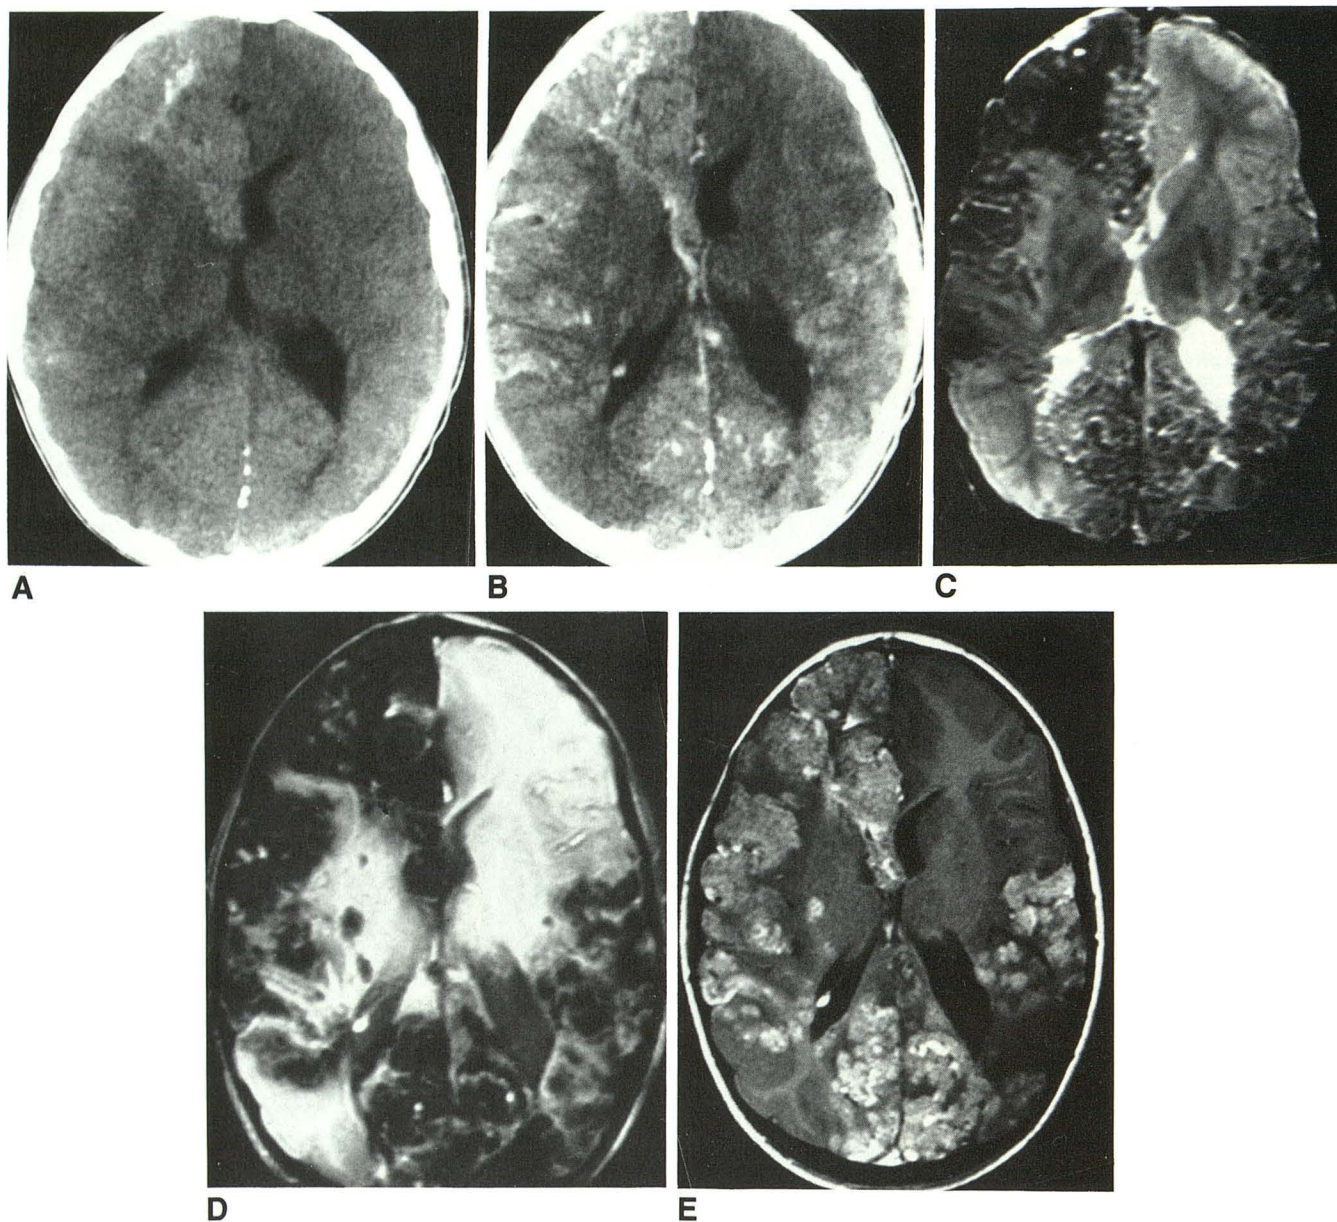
Comparative roles of CT, MR, contrast-enhanced MR, and GRE techniques (case 5).
